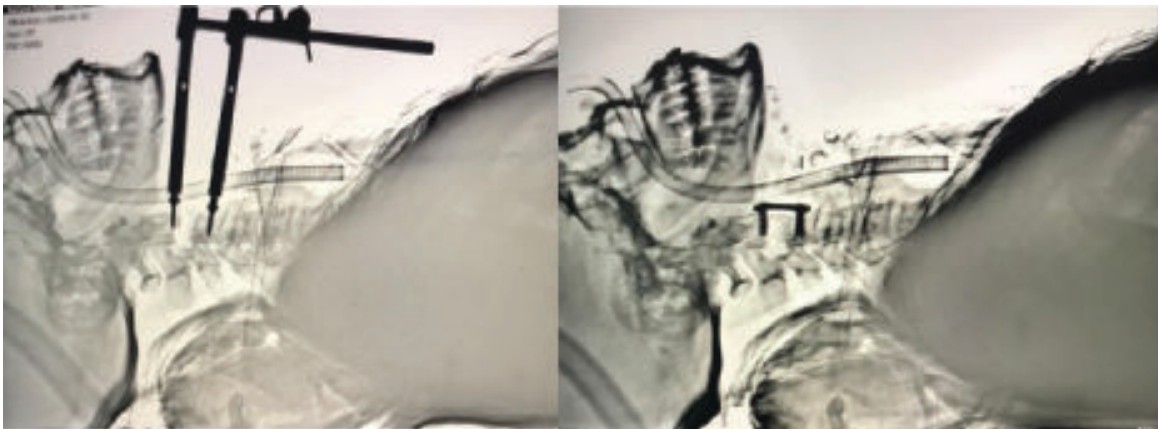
Peroperative x-ray of cervical spine
